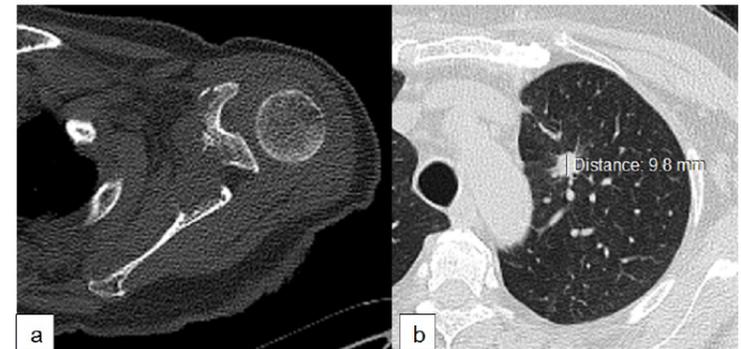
CT shows an ill-defined lytic lesion destroying the body of the scapula. The patient searched medical help because of shoulder pain. A characteristic tumoral spiculated nodule of less than 1,0 cm was found in the same exam. Courtesy from Dr. Tatiana Melo Fernandes from Marcílio Dias Naval Hospital.
